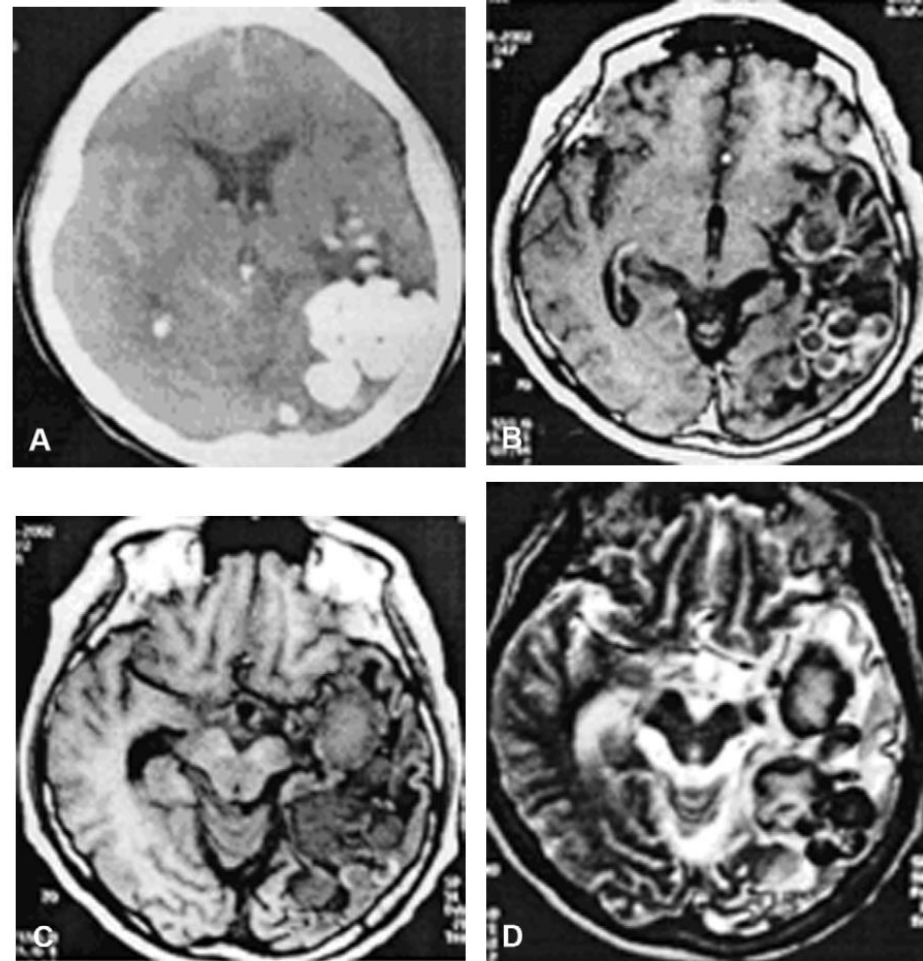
Brain MR images (A, B) of cerebral paragonimiasis from a chronic case in Korea. T2-weighted axial image shows nodules with peripheral low density and central hyperintensity and inflammatory changes in the surrounding tissues in the right temporal areas.
